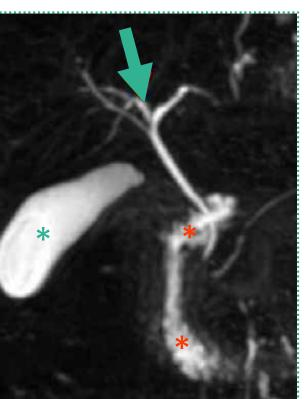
Magnetic Resonance Imaging showing showing triple biliary confluence (arrow). Gallbladder (green asterisk). Duodenum (red asterisks).
